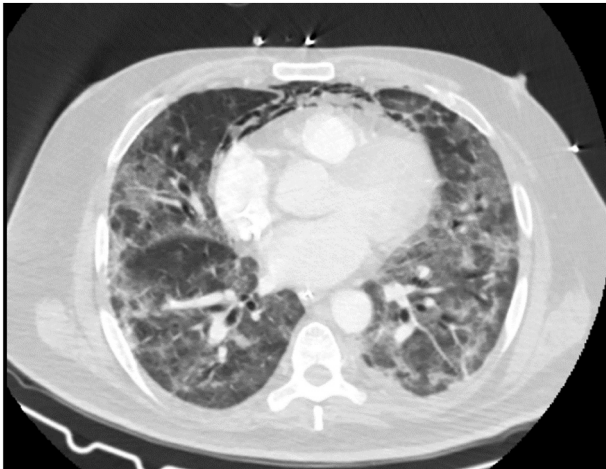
Chest tomography (CT) scan (axial section, lung window) showing extensive ground glass infiltrates in both lung fields.
